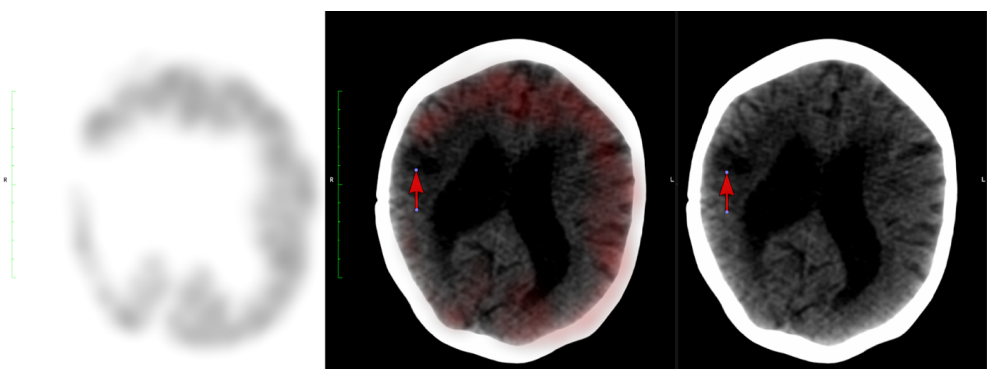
The axial CT (right), fused (middle), and PET (left) brain images obtained from a whole-body FDG PET/CT scan, which included the brain, indicate that the patient underwent a gross-total resection followed by adjuvant stereotactic radiosurgery (SRS, 18 Gy single fraction).
